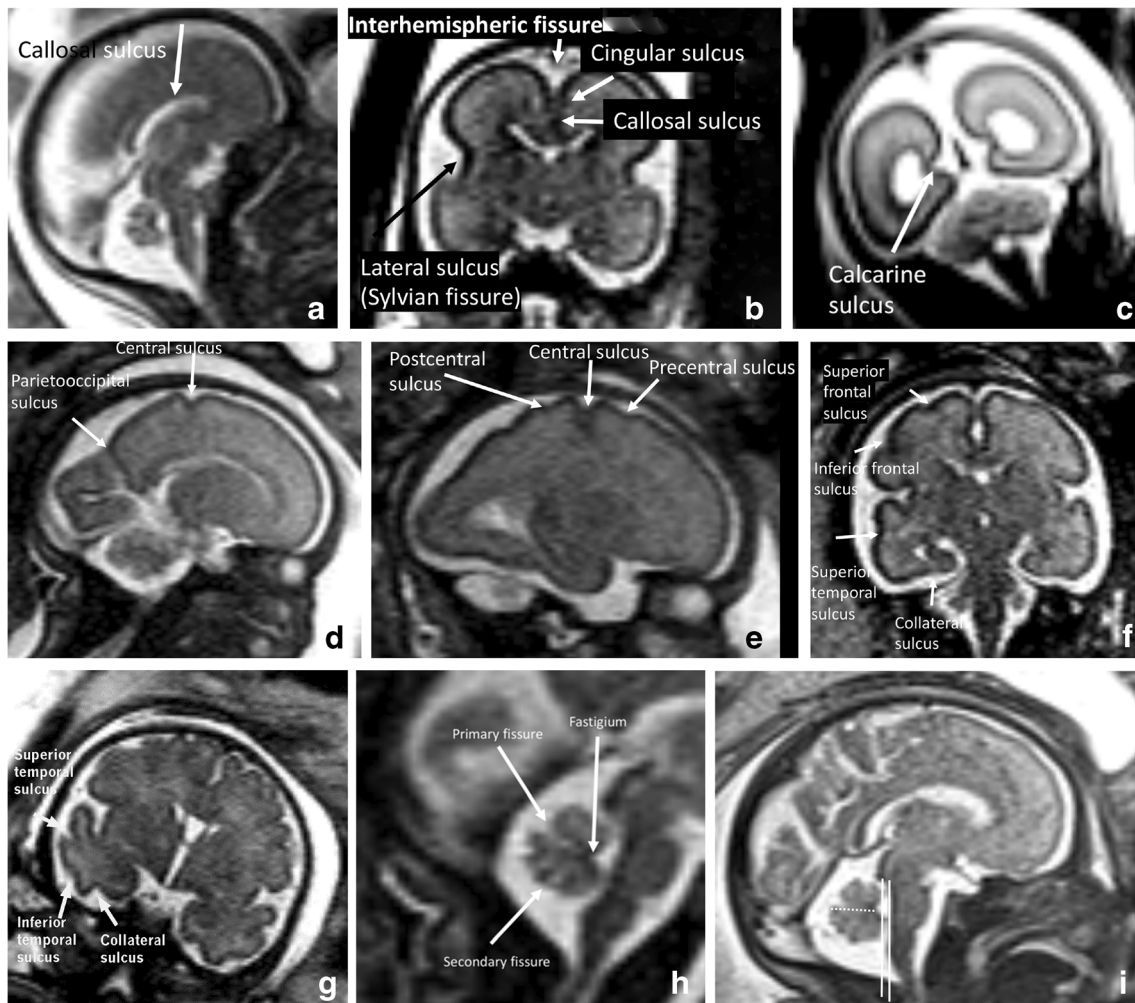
Evolution of cortical sulcation in the fetal brain seen in coronal and sagittal single-shot turbo spin-echo (SSTSE) MR images. a–g Normal progressive development of cortical sulcation demonstrated in fetuses at different gestational ages. Sagittal (a) and coronal (b and c) images demonstrate the normal brain sulcation of a 23-week fetus, sagittal (d and e) and coronal (f) images show the normal brain anatomy at 27-weeks, and coronal image (g) shows normal sulcation at 37 weeks. h, i
